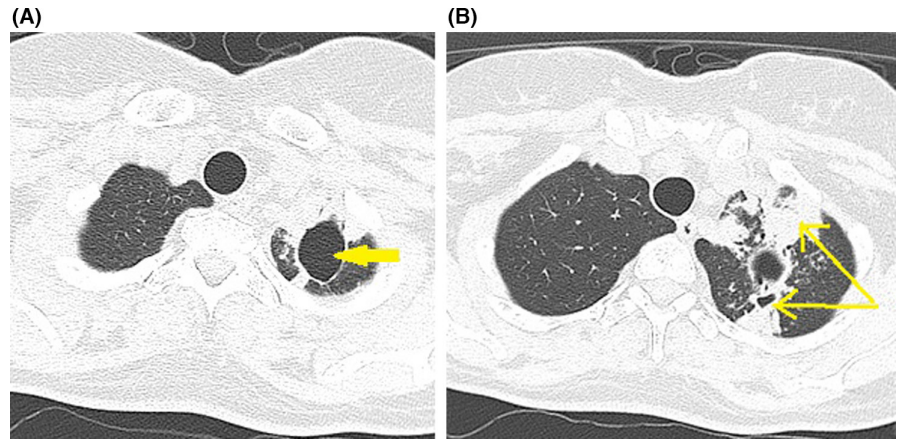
CT scan of chest axial and coronal view, showing a thin-walled cavitary lesion containing a homogeneous opacity with “crescent air” sign, suggestive of aspergilloma in the apical segment of the left upper lobe
